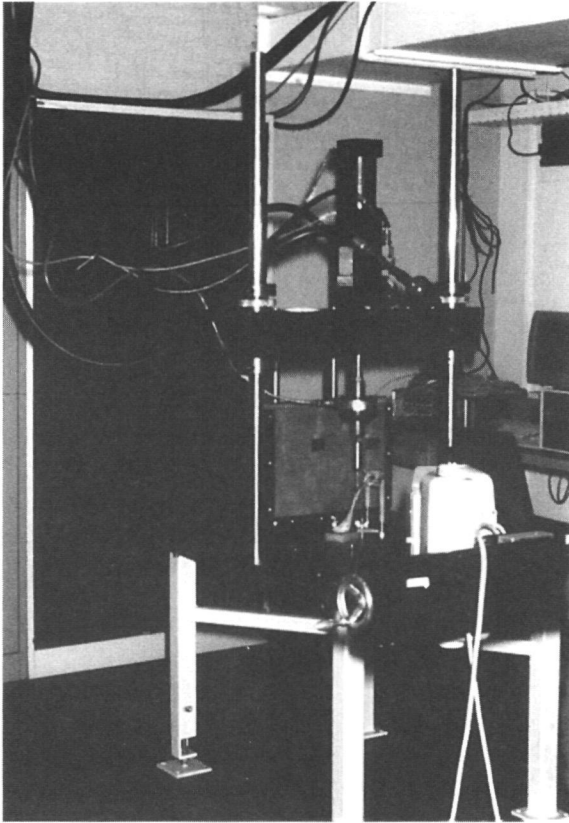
Test line up in the MTS machine and one of the roentgen tubes for stereo radiographs
